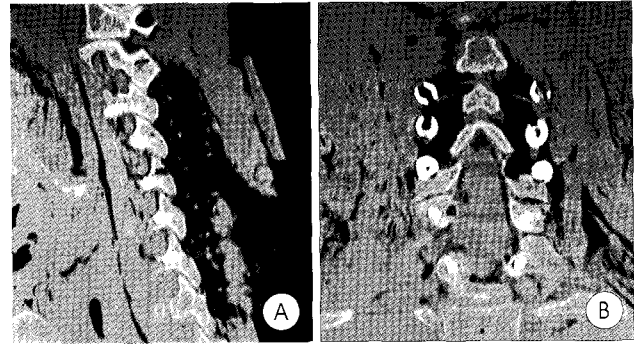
Computed tomography scans of the sagittal (A) and coronal (B) reformation created with the raw scanning data. In the sagittal reformation (A), C3 screw perforate inferiorly and others are inserted properly within the cervical pedicle. In the coronal reformation (B), both C6 screws are inserted properly within the cervical pedicle.
